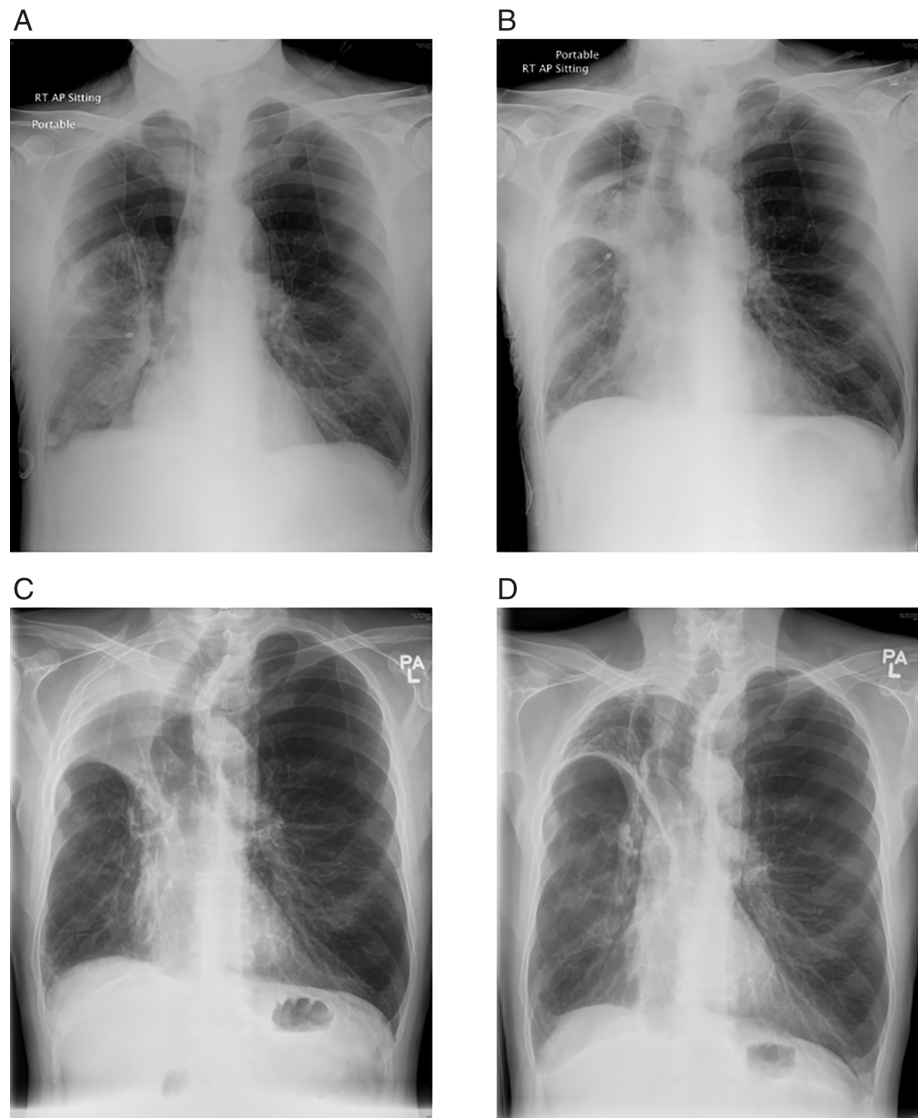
Chest radiograph at different time points. (A) immediately before endobronchial one-way valves (EBV) insertion. (B) immediately after EBV insertion. (C) 5 weeks after EBV insertion. (D) 40 months after EBV insertion.
